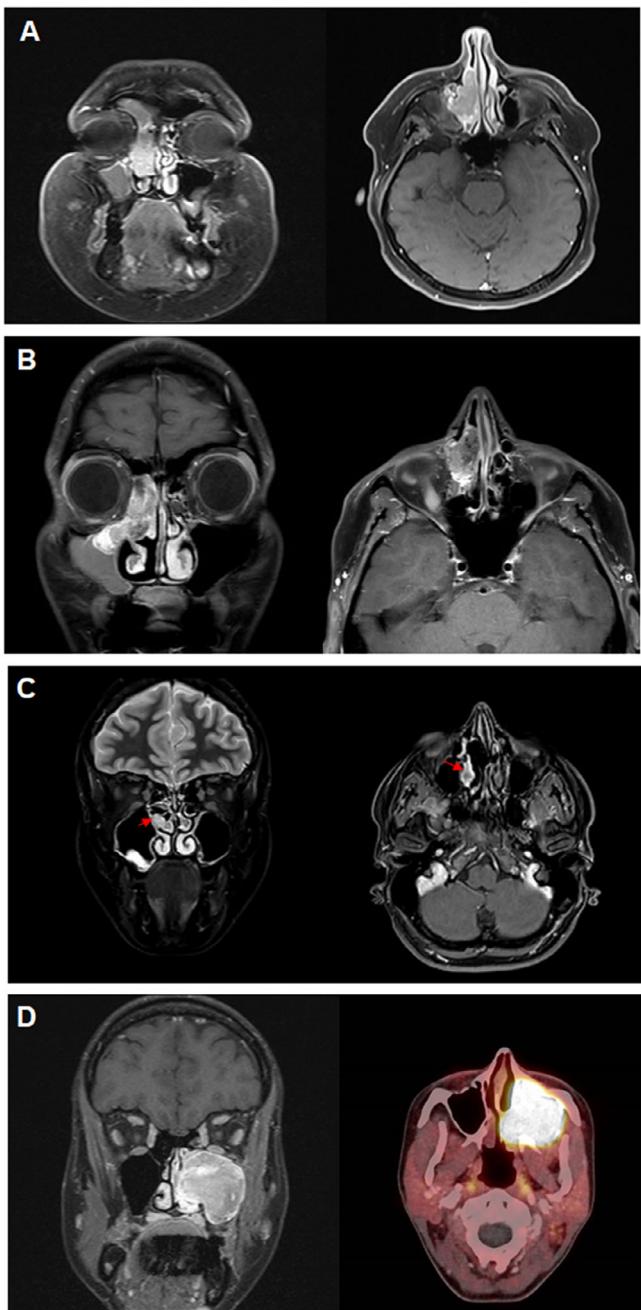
(A) Case 1: contrast-enhanced magnetic resonance imaging (MRI) scan (T1 coronal and axial) shows an hyperenhancing lesion centered on the right ostiomeatal complex, with no relation to the skull base and olfactory fissure. (B) Case 2: contrast-enhanced MRI scan (T1 coronal and axial) shows an hyperenhancing lesion centered on the right lacrimal bone, with no relation to the skull base and olfactory fissure. (C) Case 3: contrast-enhanced MRI scan (coronal, STIR, and axial, T1) acquired before incomplete resection of the tumor performed elsewhere shows an hyperenhancing lesion (arrows) centered in posterior portion of the right ostiomeatal complex, with no relation to the skull base and olfactory fissure. (D) Case 4: T1 coronal contrast-enhanced MRI scan and axial ^{68}Ga -DOTATOC PET-CT show a lesion centered in the left maxillary sinus, with no relation to the skull base and olfactory fissure.
